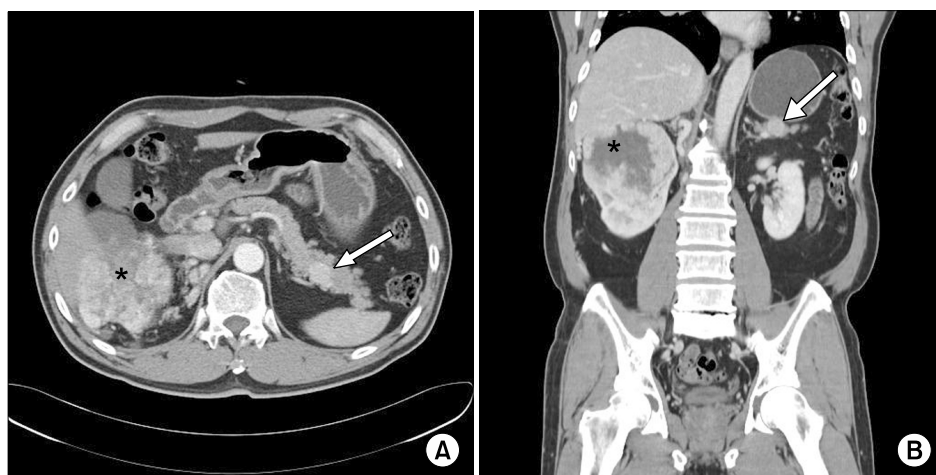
Axial (A) and coronal (B) contrast-enhanced computed tomography scan images show a well-defined homogeneously enhanced mass in the tail of the pancreas (arrow). A heterogeneously enhanced mass with central necrosis was also detected in the right kidney (*), suggesting renal cell carcinoma.
